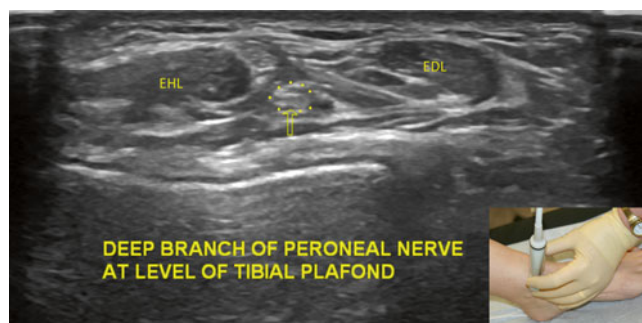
Ultrasound image of the deep peroneal nerve at the tibial plafond. EHL extensor hallucis longus, EDL extensor digitorum longus (Image courtesy of Michael Brown, MD)
